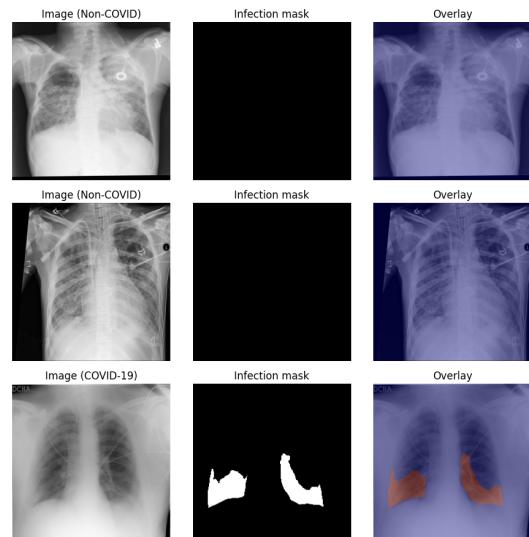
Sample X-ray images with their infection masks (overlay).
